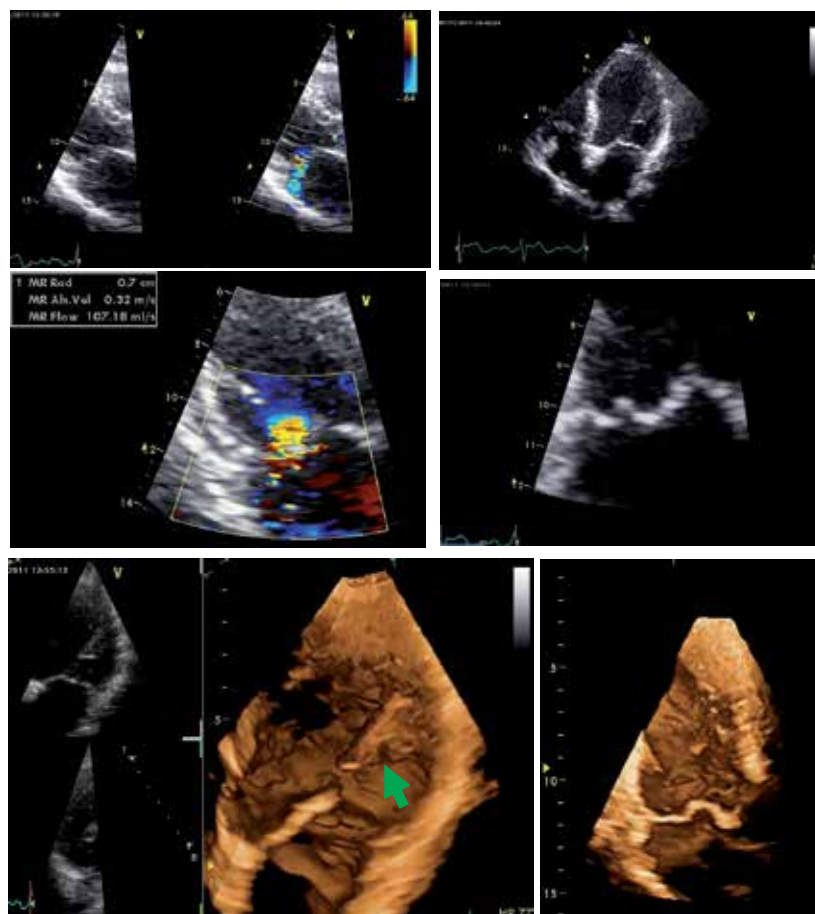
Acute severe structural ischemic mitral regurgitation due to transection of papillary muscle (2D TEE intraoperative exam). Note the loss of coaptation due to complete rupture of papillary muscle and flail (arrows). Both patients, with hemodynamic instability, were transferred to Cardiac Surgery Dpt. the same day of the transthoracic diagnosis. An emergency mitral valve replacement and CABG was successfully performed after coronary angiography.
